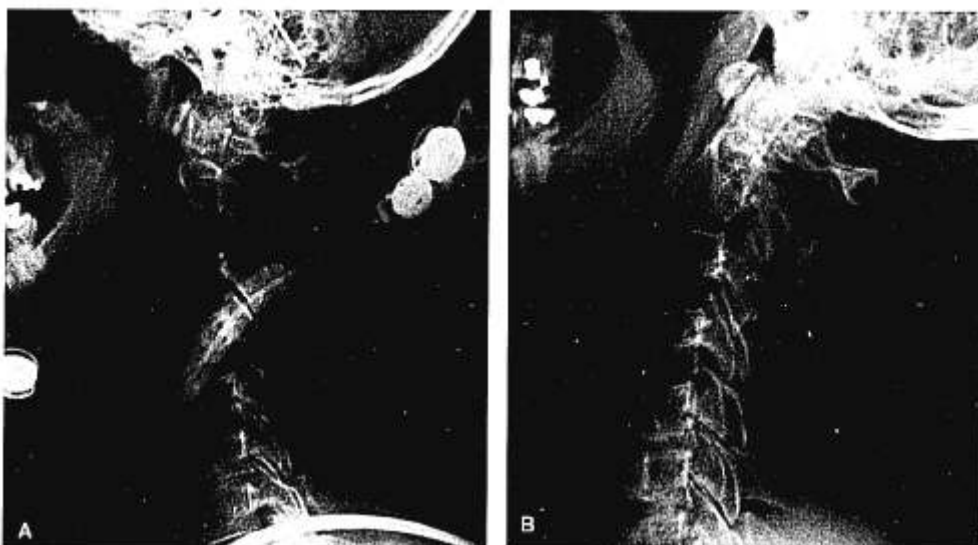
Patient had a two-level fusion at C5-6 and C6-7 with autologous iliac crest without anterior cervical plate stabilization. A: The C6-7 disc space bone graft collapsed in the immediate postoperative period. B: The patient went on to have a pseudarthrosis at C6-7 with motion on flexion extension lateral radiographs.
